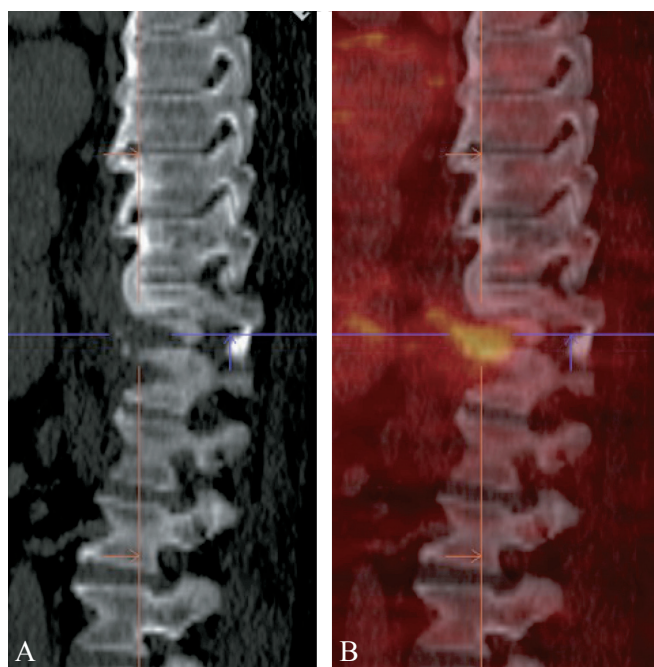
[¹⁸F]FDG PET/CT assembly showing linear uptake in the T10-T11 space indicative of discitis. CT (A) and fused sagittal PET/CT (B) images.
